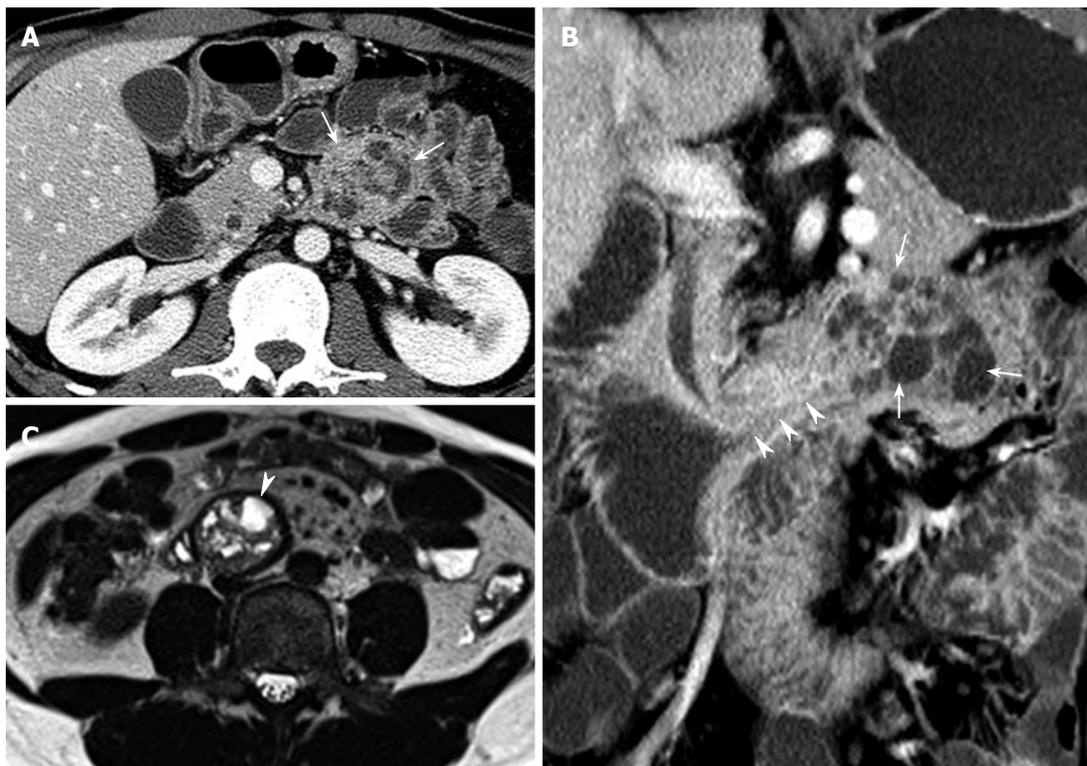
CT and MRI findings. A: Axial portal venous-phase CT scan showing an intraluminal round mass (arrows) with internal multifocal low densities in the proximal jejunum; B: Coronal reformatted portal venous-phase CT demonstrating an identical configuration to the modified small bowel series showing a long stalk (arrowheads) and a well-defined mass with multifocal cystic lesions (arrows); C: A large, well-defined multi-chambered cystic mass showing high signal intensities (arrowhead) with its moved location in the third portion of the duodenum on axial T2-weighted images.
